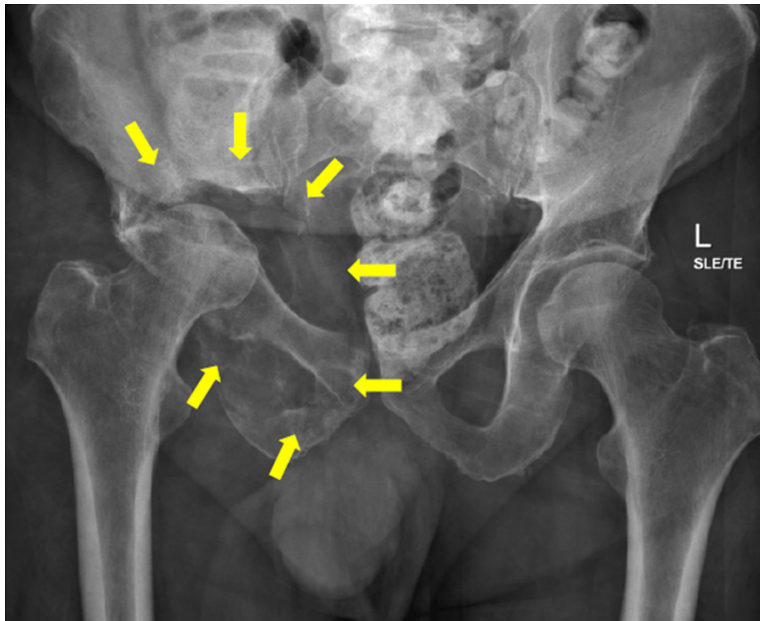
Radiographic study showing right acetabular fracture and lytic lesion (circled by yellow arrow).
